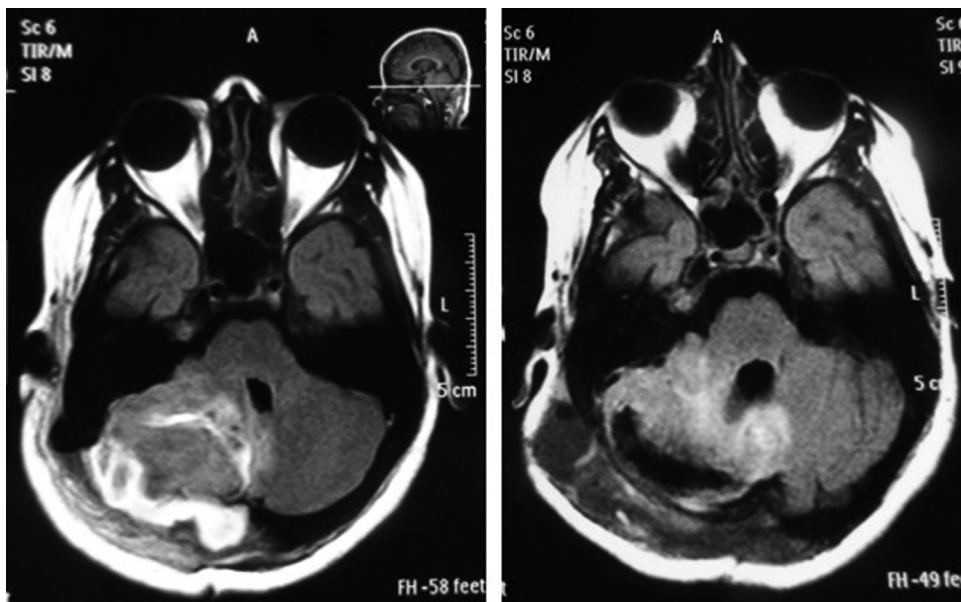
Left: T1 W contrast-enhanced MRI showing tumor recurrence. Right: Postoperative MRI.
